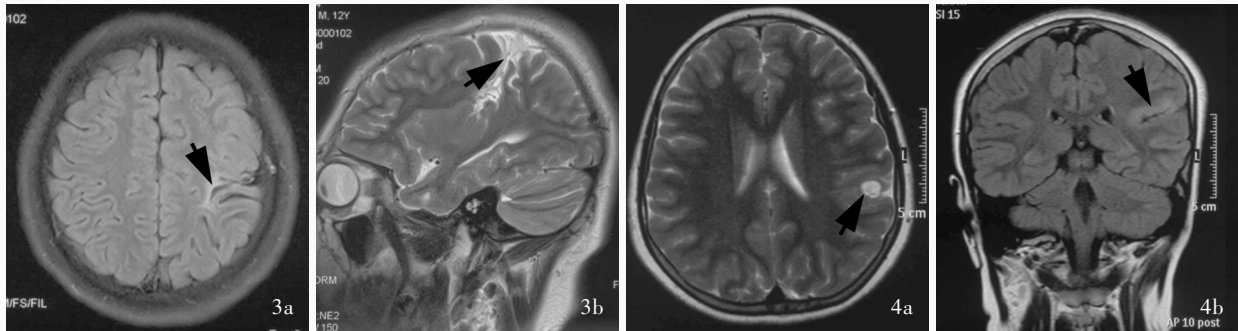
图 1 患儿头部 MRI 检查所见 3a 横断面 FLAIR 成像显示,局灶性皮质发育不良跨中央沟灰质,呈高信号(箭头所示),脑回形态异常 3b 矢状位 T₂WI 显示,局灶性皮质发育不良跨中央沟灰质,呈高信号(箭头所示),脑回形态异常 图 4 图 2 患儿头部 MRI 检查所见 4a 横断面 T₂WI 显示,左侧额叶类圆形囊性信号影(箭头所示),邻近皮质增厚 4b 冠状位 FLAIR 成像显示,左侧额叶下方脑回增厚伴异常信号影(箭头所示)
